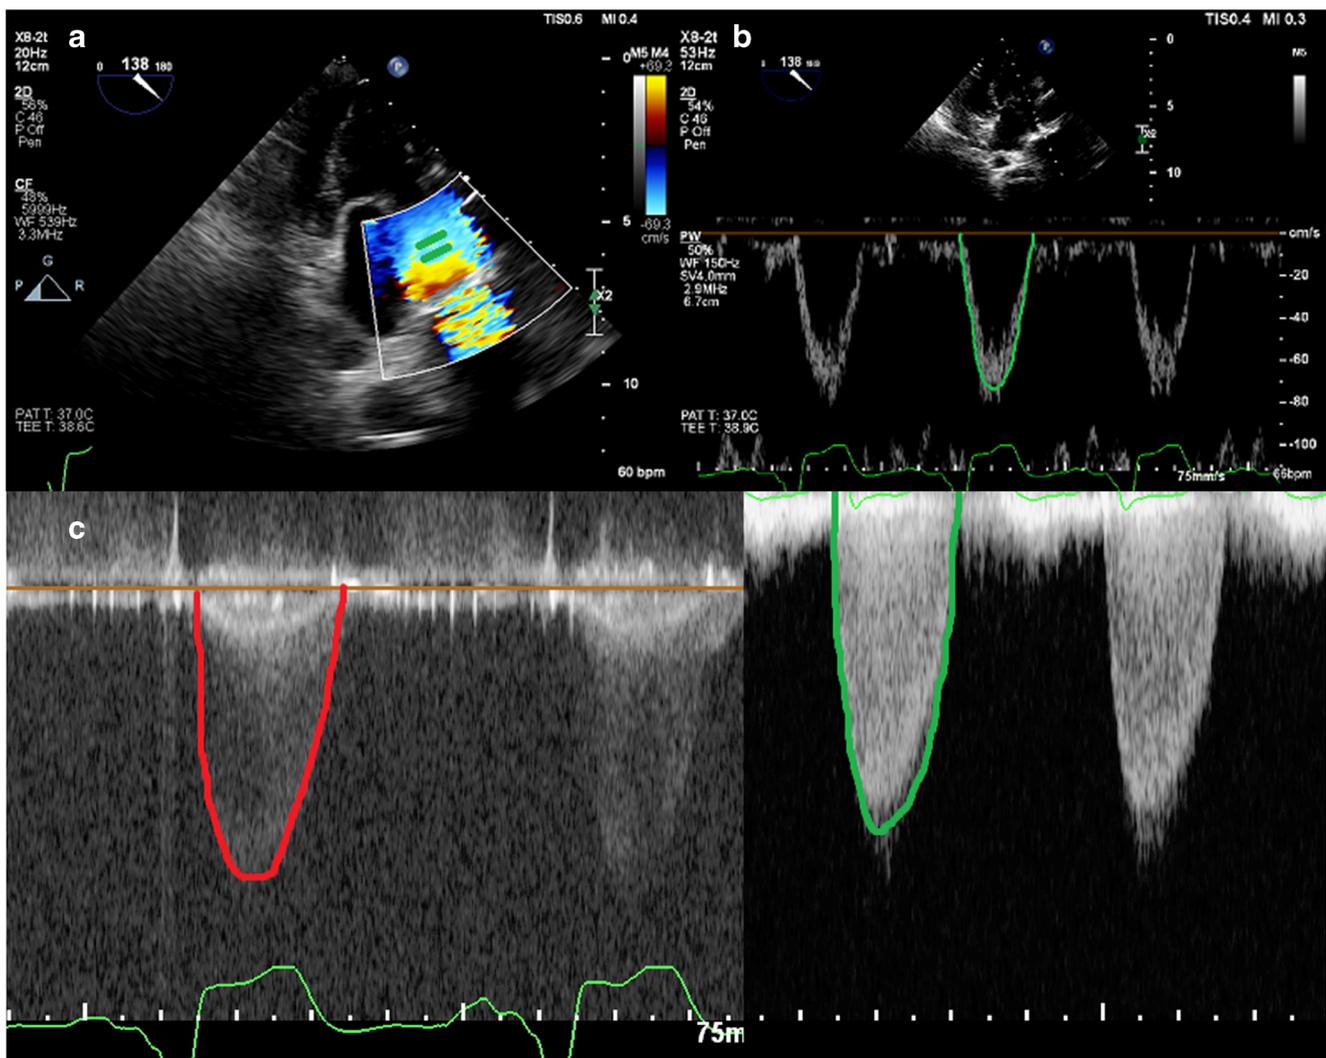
Optimal acquisition of Doppler signals is shown. The pulse wave Doppler sample volume should be placed just outside the region of flow acceleration, which can be well delineated by color Doppler (a). Placing the sample volume within this region leads to significant overestimation
